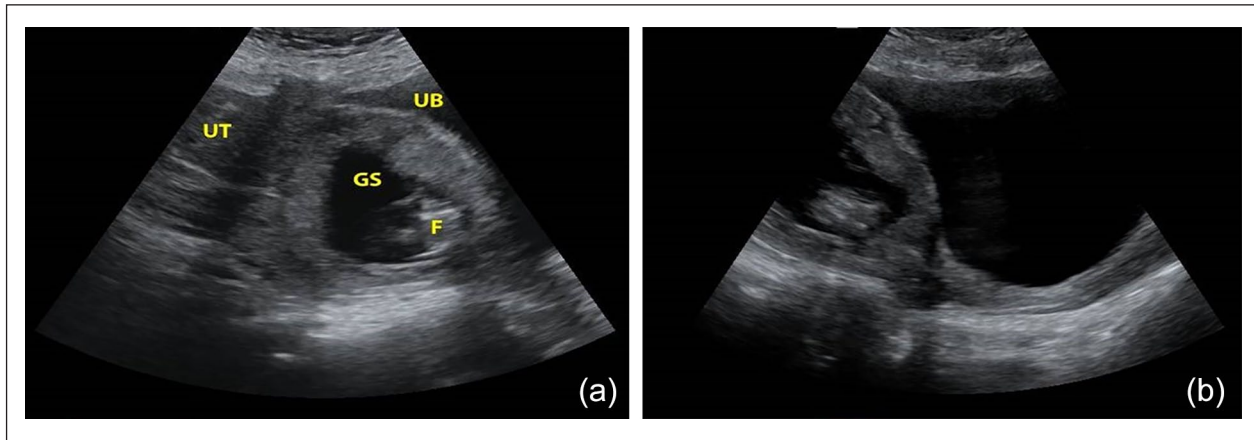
(a) A transabdominal ultrasound image shows the gestational sac in the lower uterine segment. There is no myometrium between the bladder wall and the gestational sac. The normal thickness of the myometrium is seen posteriorly. The placenta is attached to the caesarean section scar. A normal endometrial cavity is seen. (b) A transabdominal ultrasound image showing a normal cervical canal, excluding cervical ectopic.
